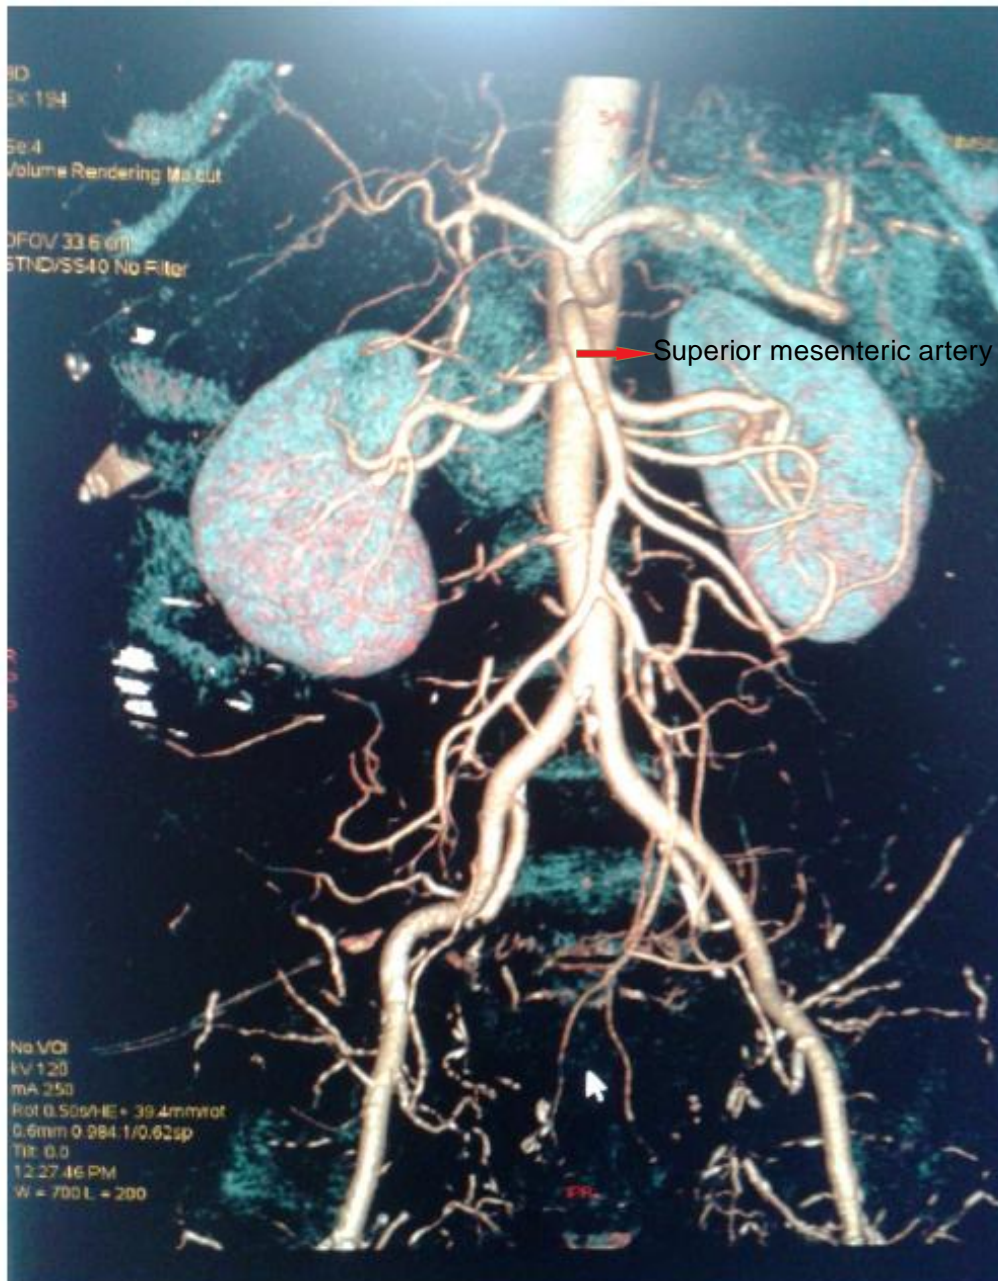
Superior Mesenteric Artery (CT Angiogram)
